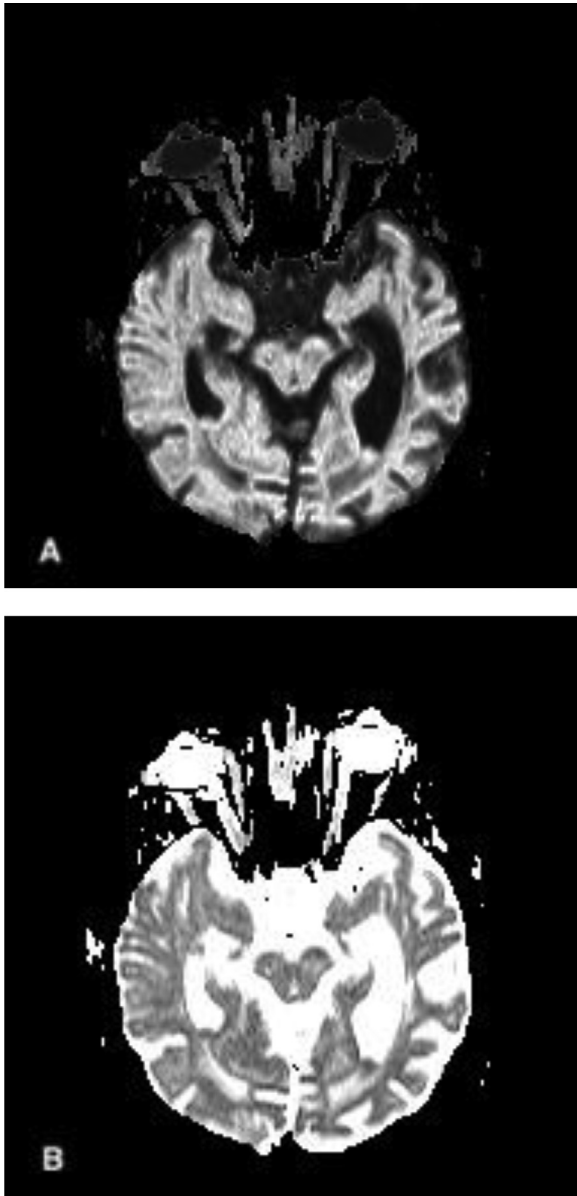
Axial diffusion-weighted magnetic resonance image and apparent diffusion coefficient (ADC) map. (A) Diffusion-weighted image shows hyperintense purulent material in the trigone of each lateral ventricle. (B) ADC map show hypointense intraventricular pus at the same level as the image A.
